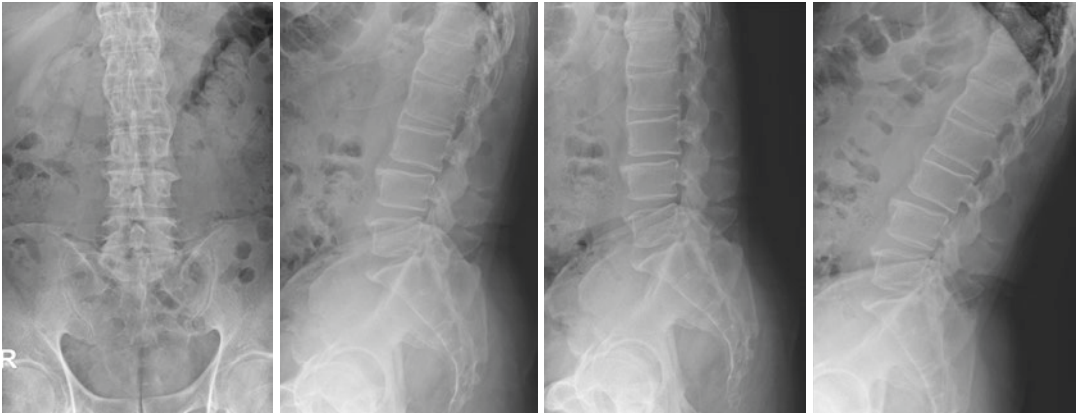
Dynamic plain radiograph shows stable retrolisthesis L3–4 level and ankylosing spine
